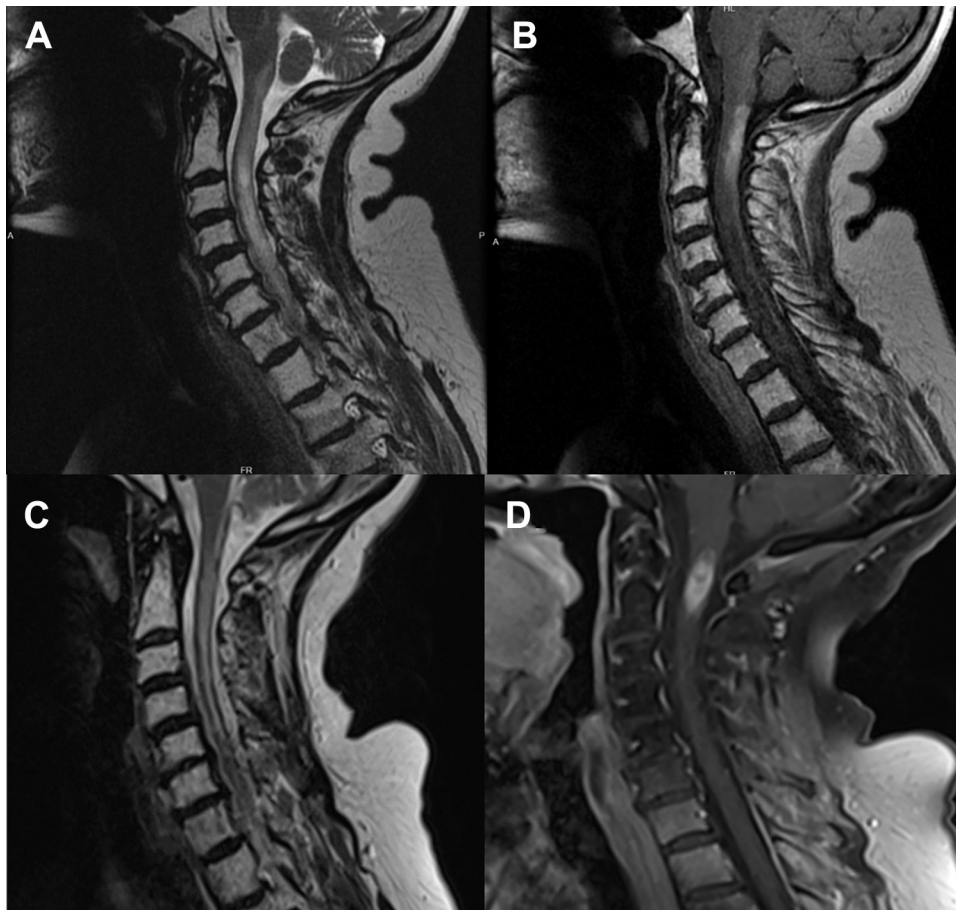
Magnetic resonance imaging upon initial presentation (T2 [A] and T1 postcontrast [B] images) and at relapse of neurologic symptoms (T2 [C] and T1 postcontrast [D] images), demonstrating abnormal signal and enhancement in the cervical spinal cord.
